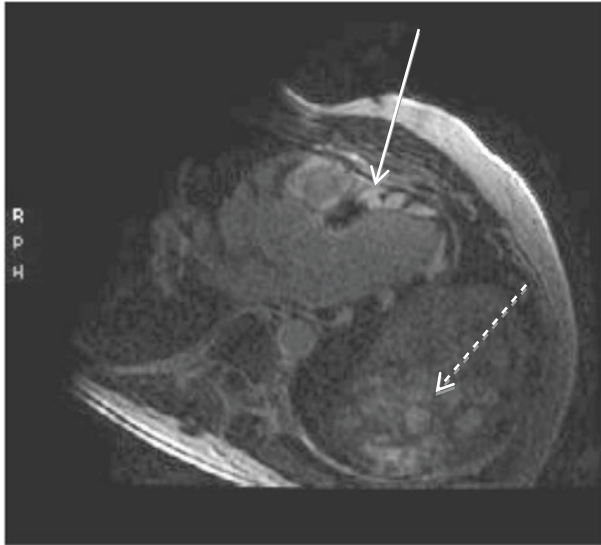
Cardiac MRI showing a three-chamber view of cardiac sarcoidosis. Relevant findings are multiple foci of scar which involve the subendocardium, mesocardium and subepicardium and transmural in spots (white arrow). Also notable is right ventricular delayed enhancement as well as multiple enhancing foci in the adjacent spleen (broken arrow)
